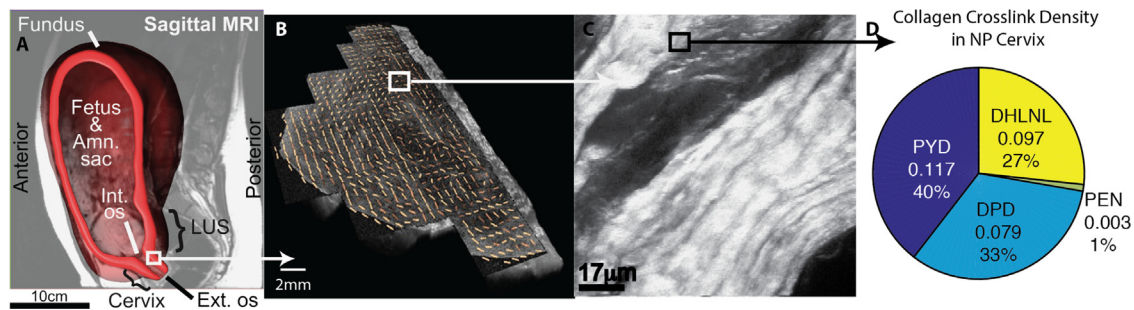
Biological length scales in the human cervix. (A) The location of the uterine cervix based on segmentation of magnetic resonance imaging (MRI) data of a 22 week pregnant patient (Fernandez et al., in press). (B) Collagen fiber directionality of an axial slice of a nonpregnant (NP) cervix imaged via optical coherence tomography (Gan et al., 2015). (C) NP cervical collagen fiber imaged via second harmonic generation (Myers et al., 2009). (D) NP cervical crosslink density (mole-per-mole basis with collagen) content, pyridinoline (PYD), deoxypyridinoline (DPD), dihydroxylysinoxonoreucine (DHLNL), pentosidine [PEN] (Zork et al., 2015).
